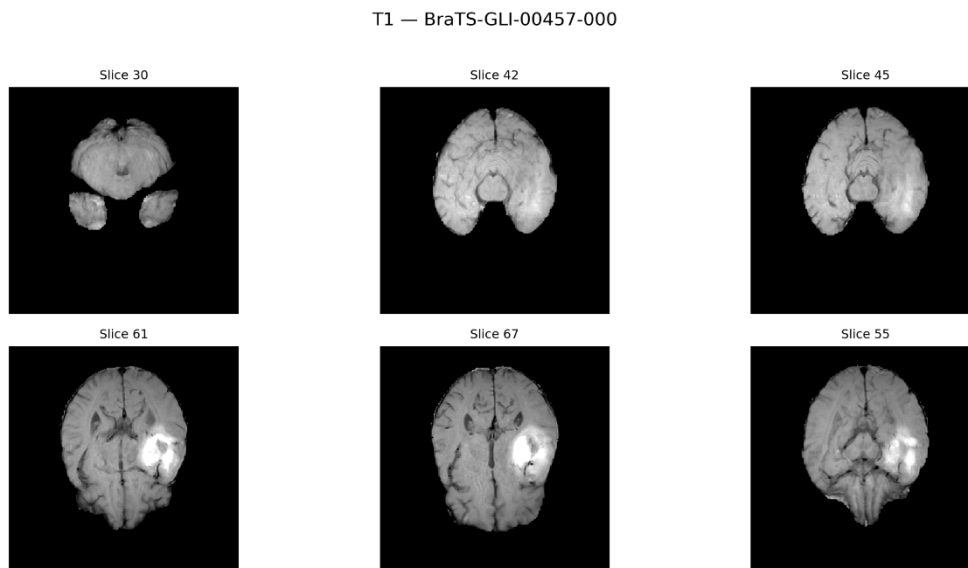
Example of T1-weighted MRI slices from the BraTS 2023 dataset with different cross-sections of the brain
